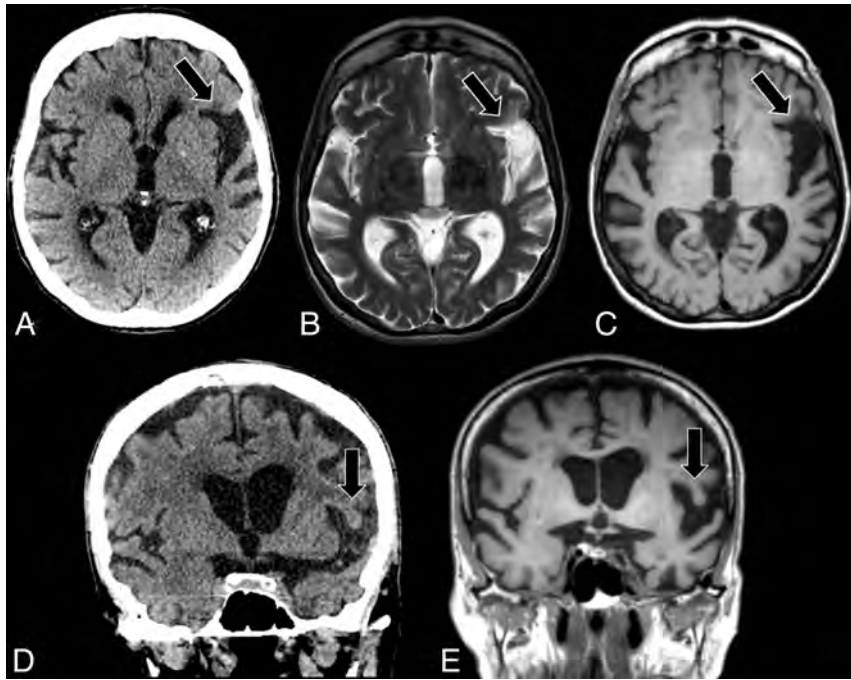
Axial CT (A), axial T2-weighted MR imaging (B), axial T1-weighted MR imaging (C), coronal CT (D), and coronal T1-weighted MR imaging (E) in a right-handed individual with apraxia of speech demonstrate asymmetric widening of the left Sylvian fissure with predominant left posterior frontoinsular atrophy (black arrows, A–E), suspicious for nvfPPA.
